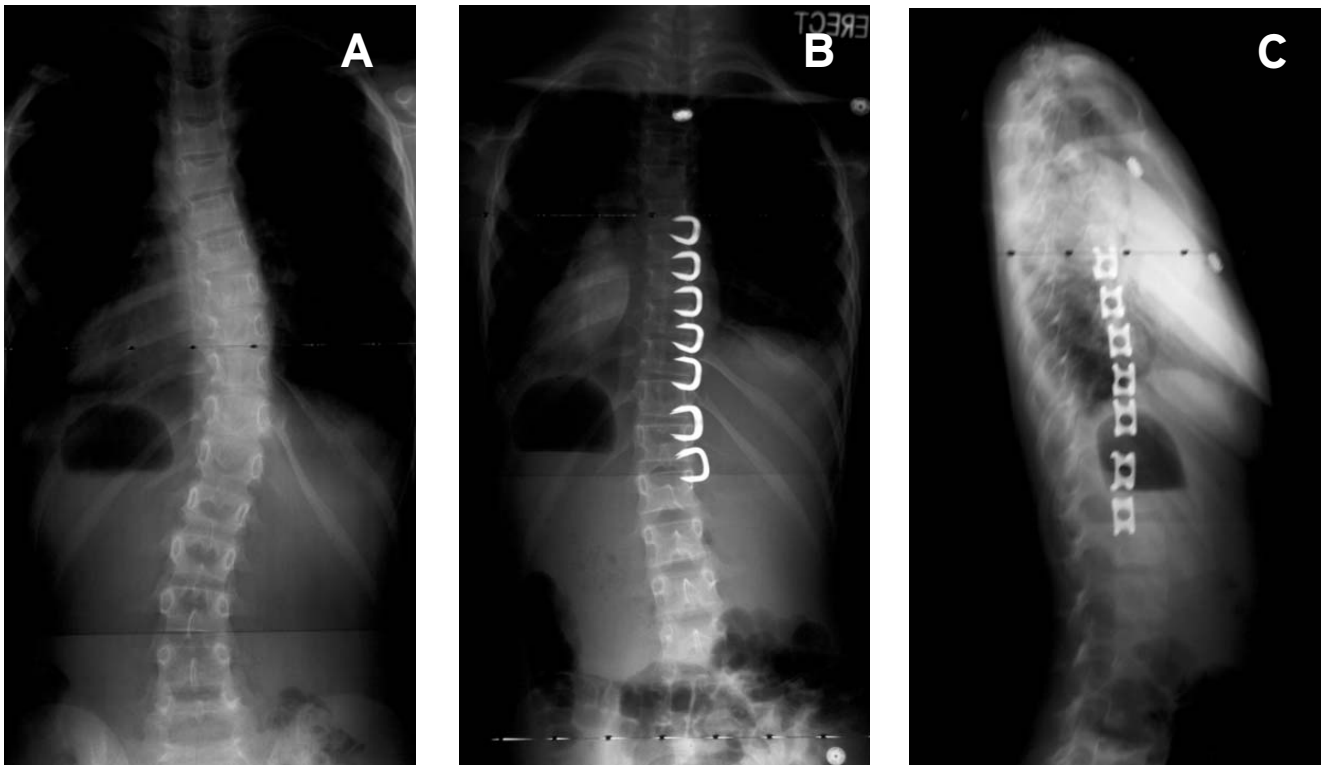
Vertebral staples inserted to limit growth on the convex side of a curve. Preoperative radiograph, posteroanterior view (A); postoperative radiographs of posteroanterior (B) and lateral (C) views
